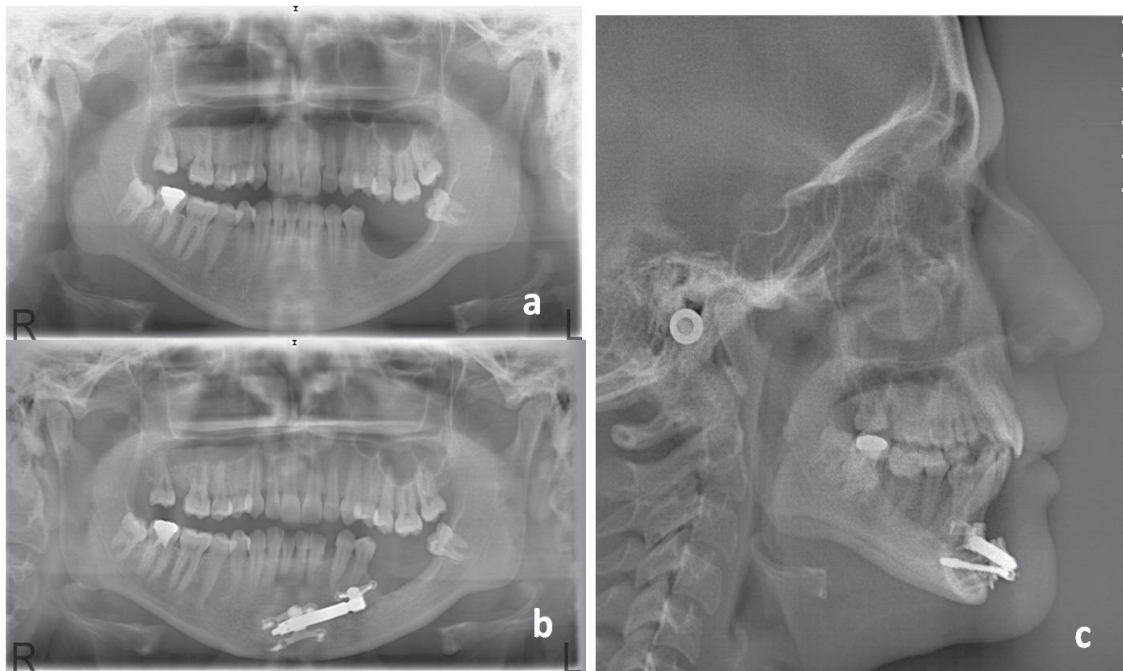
a) Pretreatment panoramic radiograph, b) Panoramic radiograph with alveolar distractor, c) Lateral cephalometric radiograph showing alveolar distractor.
